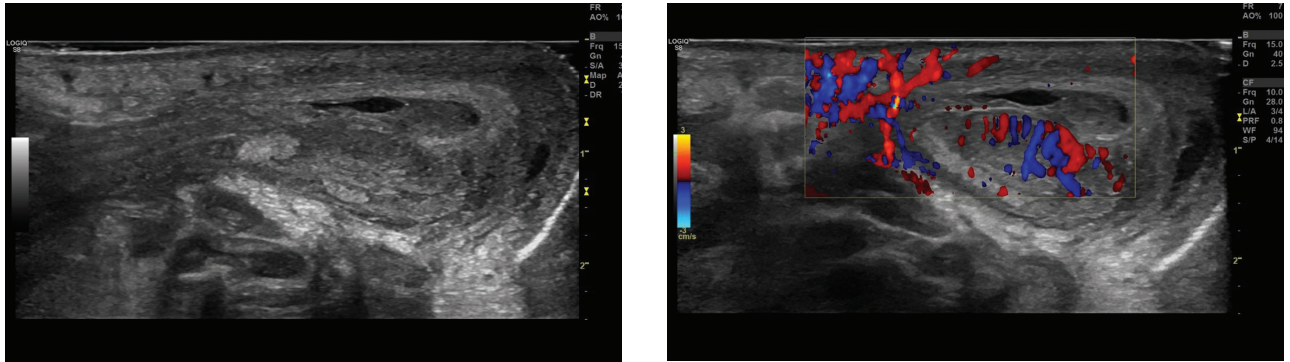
Longitudinal view of the inguinal canal and scrotum. a. Gray-scale US. b. Colour Doppler US.
